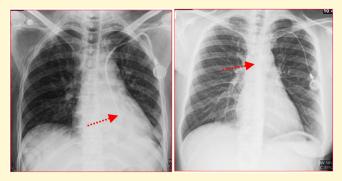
Frontal Chest Radiographs showing Chemoport (A) in mediastinum (not insitu) and (B) repositioned (tip in SVC).
